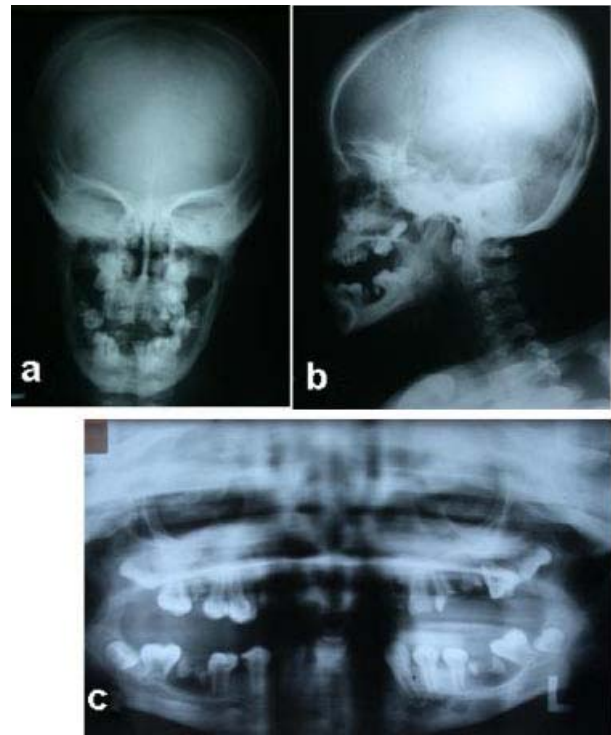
(a) PA skull radiograph and (b) lateral cephalograph showing widened diploe and hyperostosis of the cranial base. The outer and inner tables of the cranium are thin. (c) Panoramic radiograph showing taurodontism of maxillary second molars and severe alveolar bone loss caused by dental infection.
